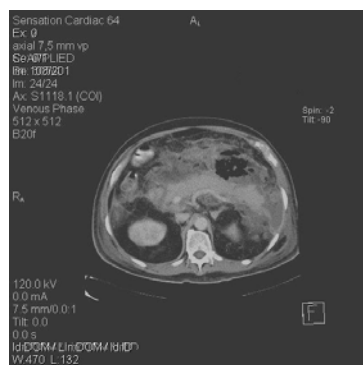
CT scan with cystic lesion in pancreatic tail, abscess formation peri pancreatic
